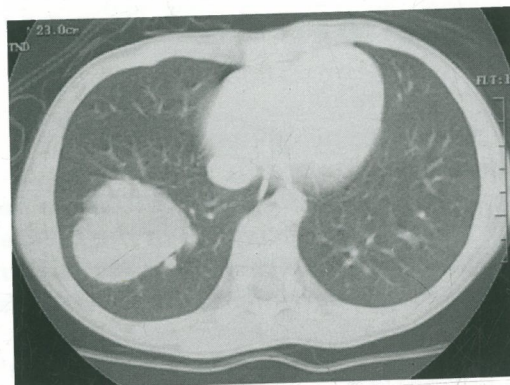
CT Scan showing right lower lobe Pseudotumor
